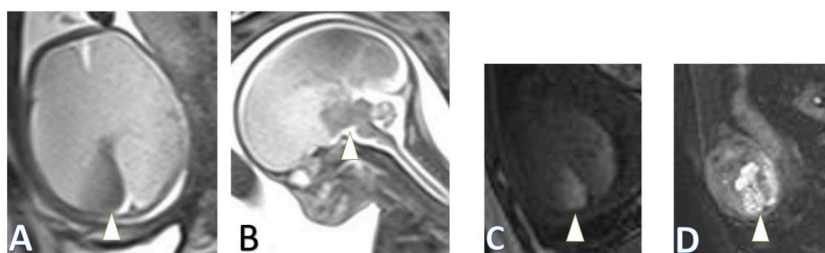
A 22-GW singleton pregnancy. A diffuse iso-hyperintensity signal was seen in both cerebral hemispheres with diffuse loss of grey–white differentiation and effacement of the sulci on HASTE (A–B). The occipital lobe, thalamus and brainstem (arrowhead) mostly displayed iso-hypointensity signals on T2WI (B), slightly high signals on T1WI (C) and extremely restricted signals on DWI (D). All of these signs indicated postbleeding changes with diffuse cerebral oedema in the brain parenchyma. The TOP procedure was performed.
